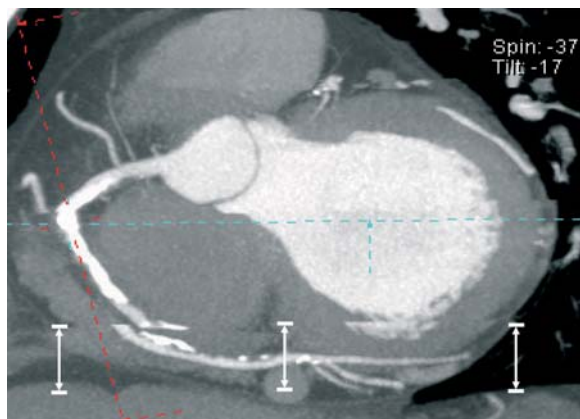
Coronary CT angiography examination using a 64-slice CT scanner. An ectopic beat during the scan results in a parallel shift of a large image slab (range described by arrows). The width of the displaced image slab is determined by the coverage of the detector. (Case courtesy of Xuan Wu Hospital, China)
